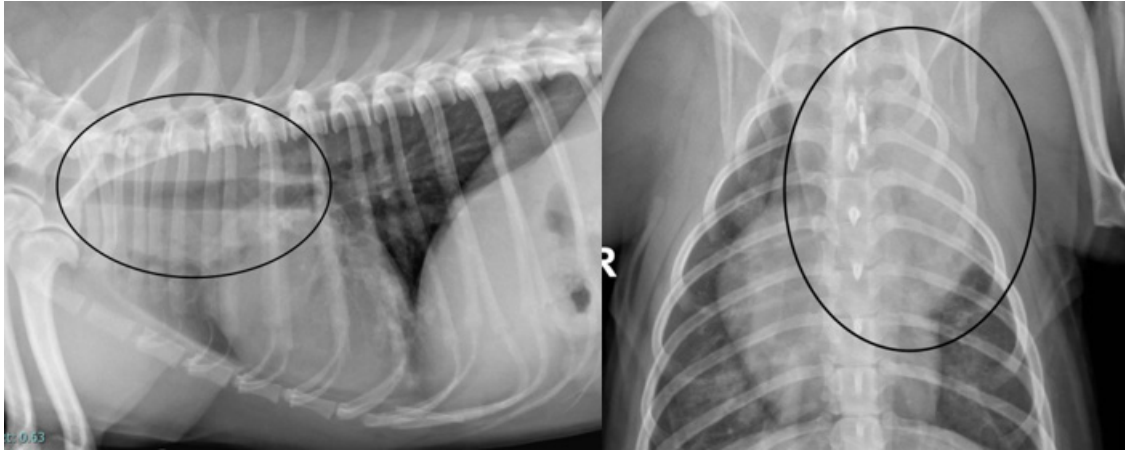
Left lateral and dorsoventral thoracic radiograph reveals a mass in the left cranial dorsal lung field.
